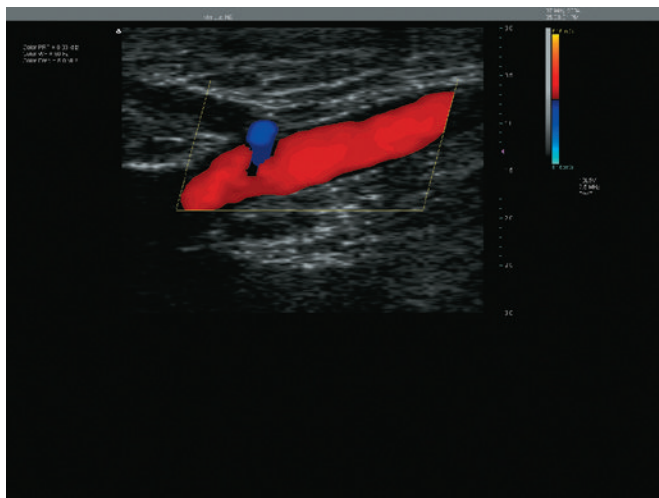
Color Doppler image of the confluence of the epigastric and great saphenous vein (GSV) showing reflux into the GSV. (Taken with Terason 2000 system; Terason, Burlington, MA.)
